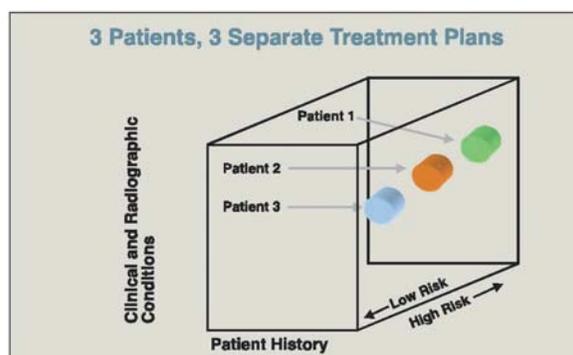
Diagnosis when level of risk is included along with clinical and radiographic conditions and patient history for the same three patients seen in Figure 4a who now appear to require different treatments
